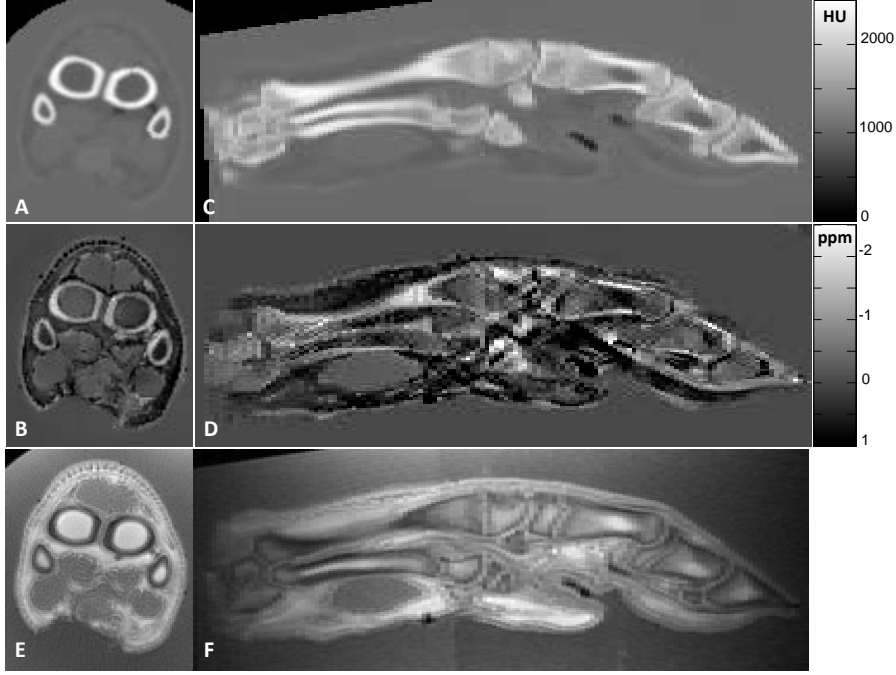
Comparison of CT images (A,C) with correspondent planes of reconstructed QSM (B,D) and ultra-short ($40 \mu s$) echo magnitude (E,F). Note the homogeneous diamagnetic appearance of cortical bones and overall fair correspondence between regions of high HU and low susceptibility values.
